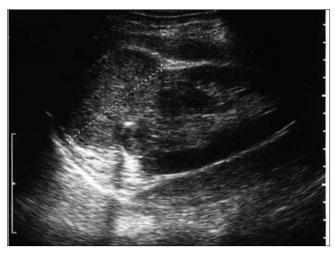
Case I. Transabdominal ultrasound examination revealing a right kidney with a hypoechoic mass, 40 mm in diameter, located in its lower part.
